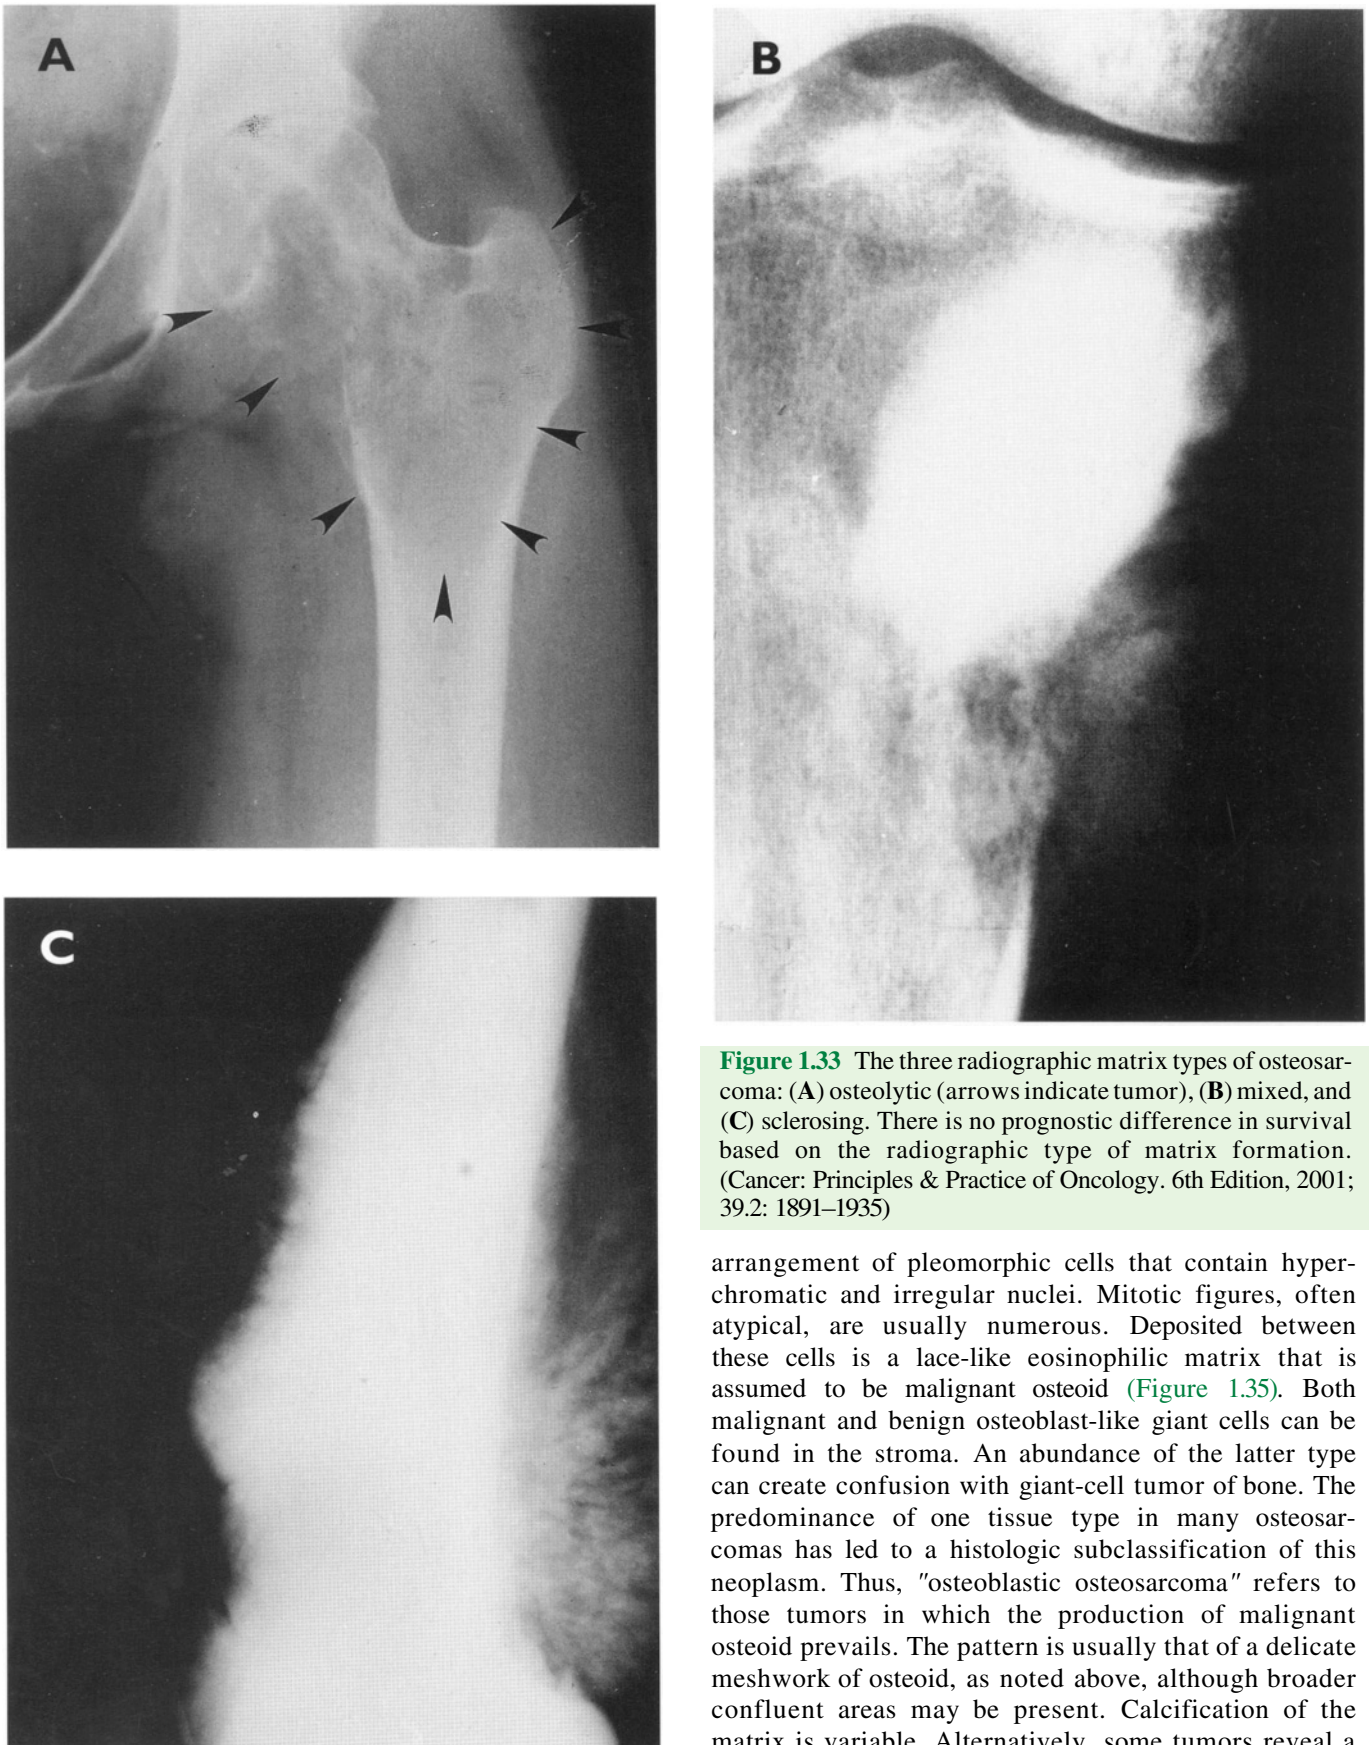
The three radiographic matrix types of osteosarcoma: (A) osteolytic (arrows indicate tumor), (B) mixed, and (C) sclerosing. There is no prognostic difference in survival based on the radiographic type of matrix formation. (Cancer: Principles & Practice of Oncology, 6th Edition, 2001; 39.2: 1891–1935)
